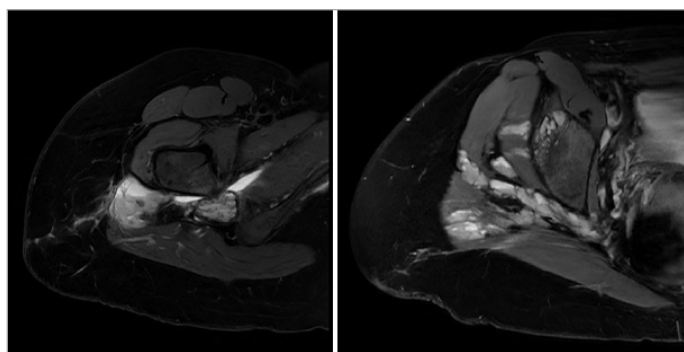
MRI performed after surgery.
